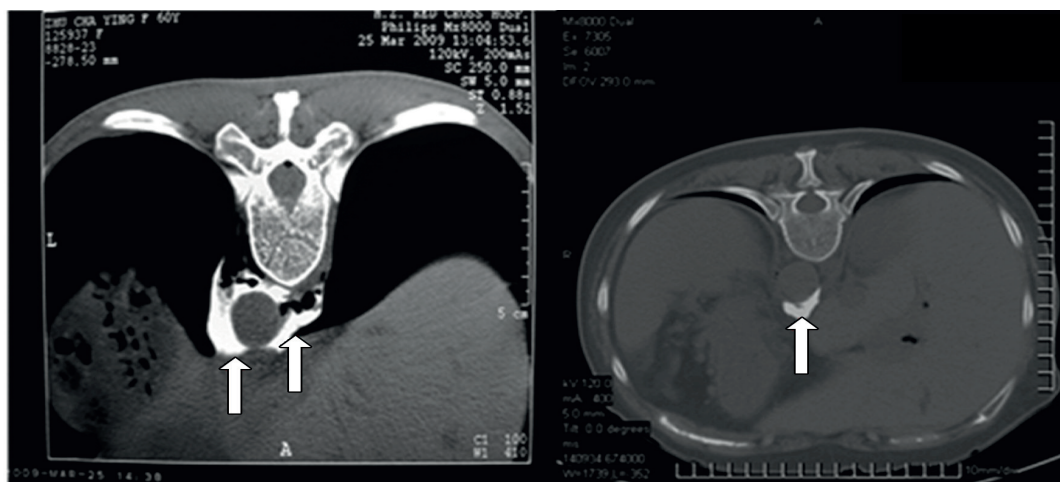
Computed tomography images. Contrast medium spread during the celiac plexus block through the T12-L1 intervertebral disc. CTs show adequate spread of contrast medium (arrows) around the target plexus. Left, double needles. Right, single needle.
